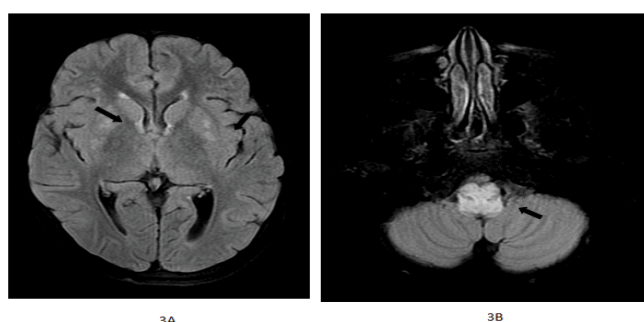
MRI of brain (a) T2 FLAIR demonstrating hyperintensities (black solid arrows) in bilateral lentiform nuclei and (b) brainstem.
